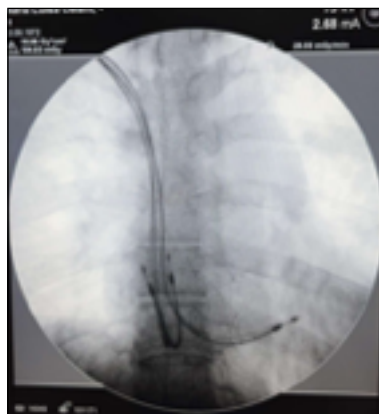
Chest radiograph showing the presence of two atrial leads and one ventricular lead, demonstrating the distal segment of the fractured atrial lead abandoned intravascularly and in the right atrium.
